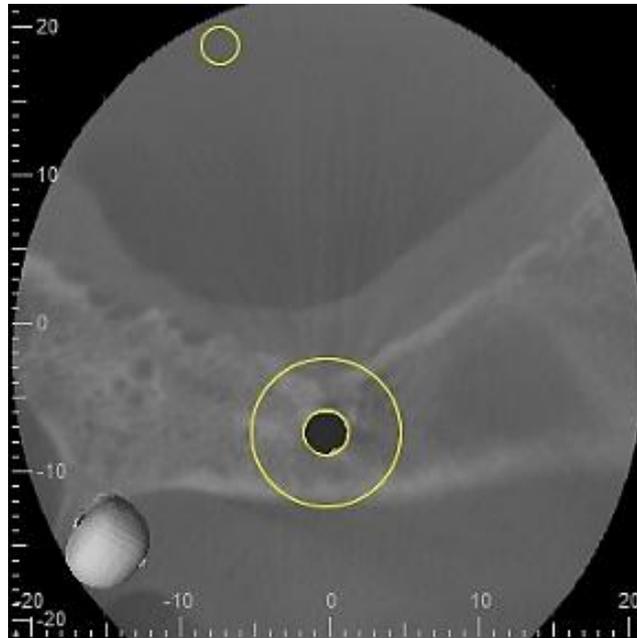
CBCT and the three axial reconstructions.
